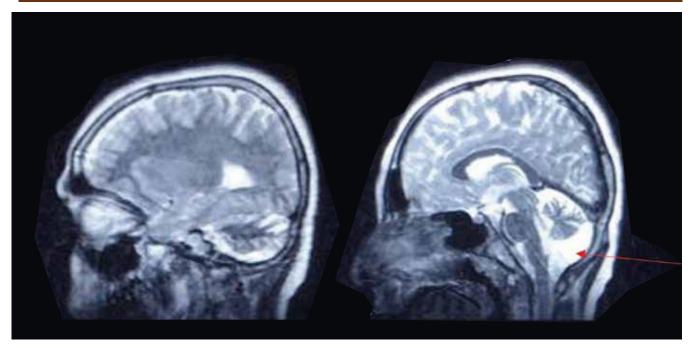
MRI brain T2-weighted sagittal images showing cerebellar atrophy with prominent CSF space (arrow).
